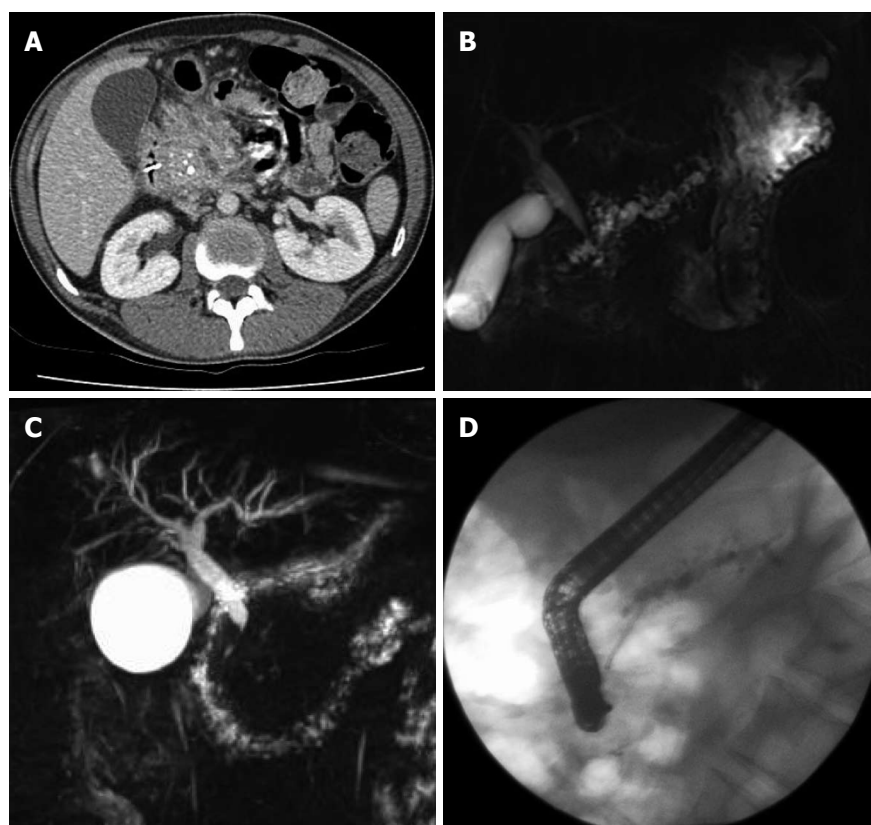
Computed tomography demonstrating enlarged head of pancreas with coarse calcification and a dilated main pancreatic duct (A), magnetic resonance cholangiopancreatography showing a tortuous, dilated pancreatic duct (B), inflammatory stricture of the distal common bile duct (C), endoscopic retrograde cholangiopancreatography showing a stent placed in a dilated pancreatic duct (D).
